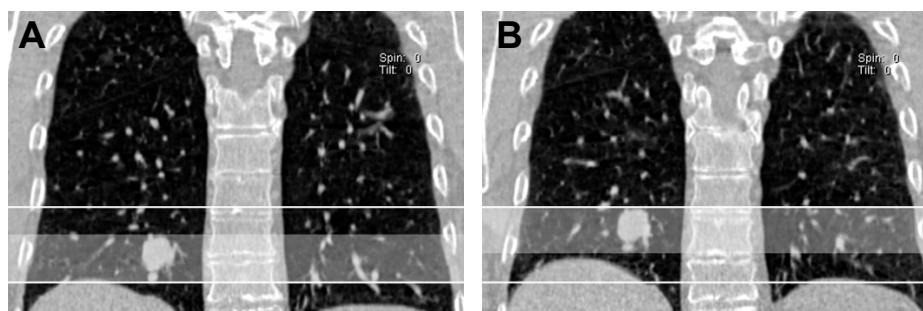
Example of two four-dimensional respiratory-gated multislice spiral computed tomography volumes with a coronal plane at different time points (A, B) within the respiratory cycle. The corresponding positions of the right lower lobe lung tumor are shown.
